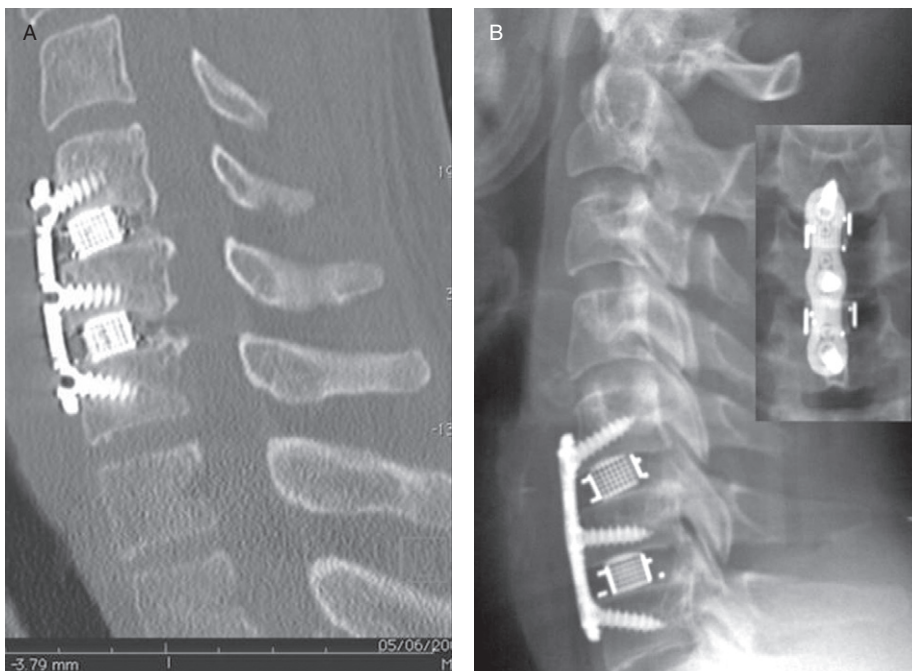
Fine-cut CT scan (A) demonstrating fusion of a two-level graft with plating at 3 months post-operatively with pain-free range of motion, and the day-1 postoperatively corresponding neutral sagittal and antero-posterior X-rays (B).
